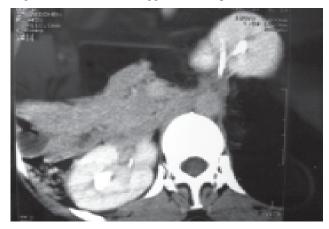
CT scan showing huge retroperitoneal lipoma displacing the left kidney anteriorly
